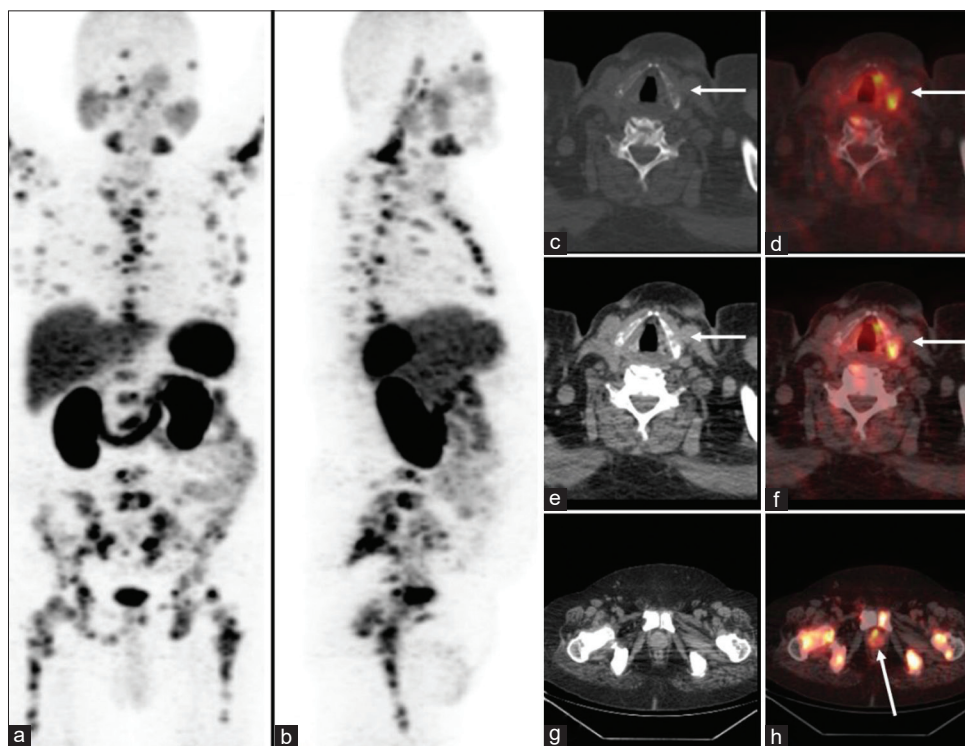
^{68}Ga -prostate-specific membrane antigen positron emission tomography/computed tomography scan, anterior and lateral maximal intensity projection (a and b) image suggestive of multiple PSMA avid metastatic lesions. Axial computed tomography and fused positron emission tomography/computed tomography images (c-f) showing prostate-specific membrane antigen avid lesion in left lamina of the thyroid cartilage and few prostate-specific membrane antigen avid sclerotic skeletal lesions. Axial computed tomography and fused positron emission tomography/computed tomography images (g and h) showing prostate-specific membrane antigen avid primary lesion in the prostate gland and few prostate-specific membrane antigen avid sclerotic skeletal lesions
